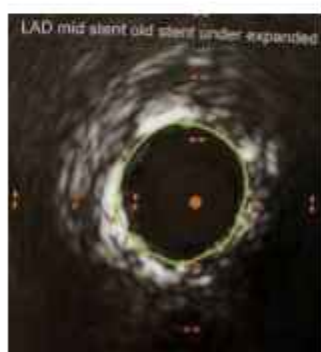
Intravascular ultrasound image showing stent under expansion
